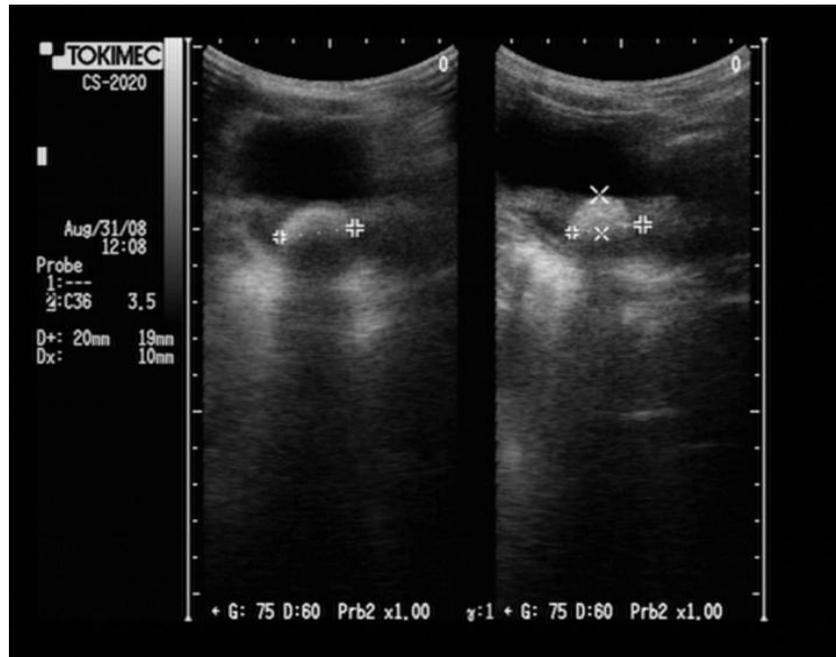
Short axis UB sonogram in TB patients; Vesicle stone with UB cystitis
